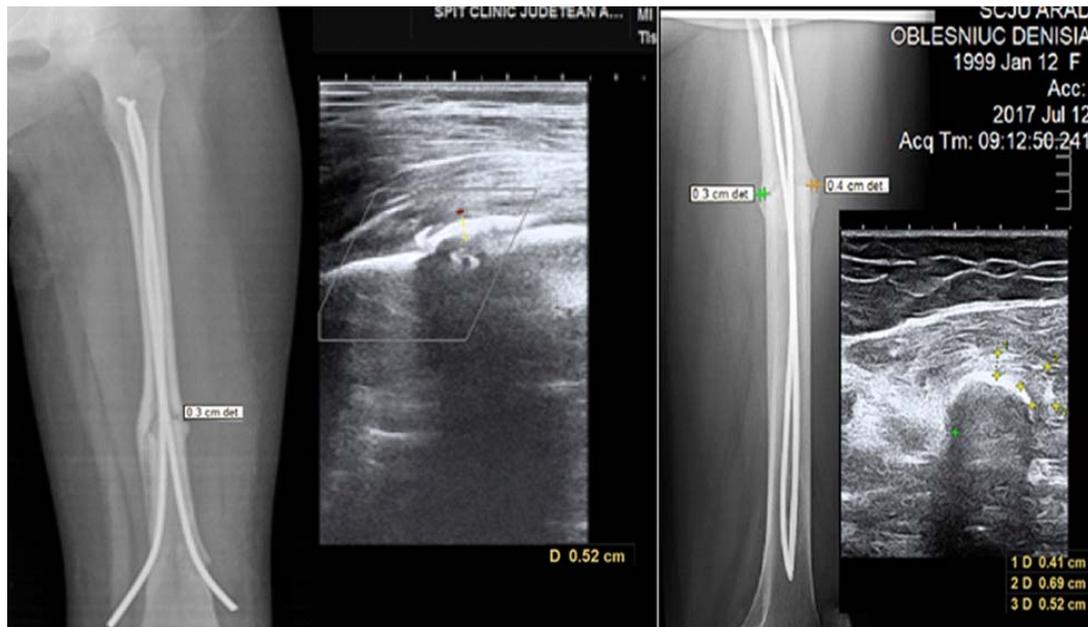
Comparative radiological imaging aspects (AP and LL incidence) and ultrasound (longitudinal and cross section) of the bone callus at 30 days postosteosynthesis with TEN, femoral shaft fractures.
